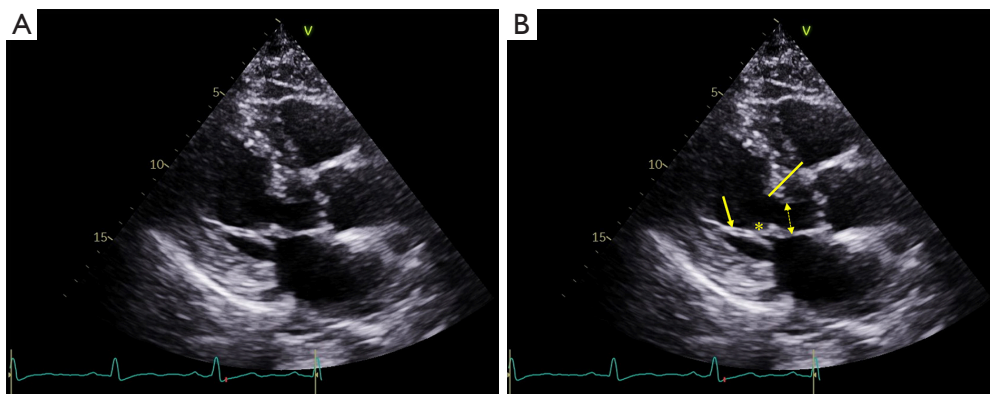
Asymmetric interventricular septal thickening in hypertrophic cardiomyopathy. (A) A parasternal long-axis view at end-diastole; note the sigmoid septum morphology; (B) the solid line measures the maximum thickness of the basal interventricular septum at 20 mm, the double arrowhead highlights left ventricular outflow tract narrowing, the asterisk highlights a thickened mitral valve with an anteriorly-displaced coaptation point, and the single arrowhead points to short and fibrotic chordae tendinae.
